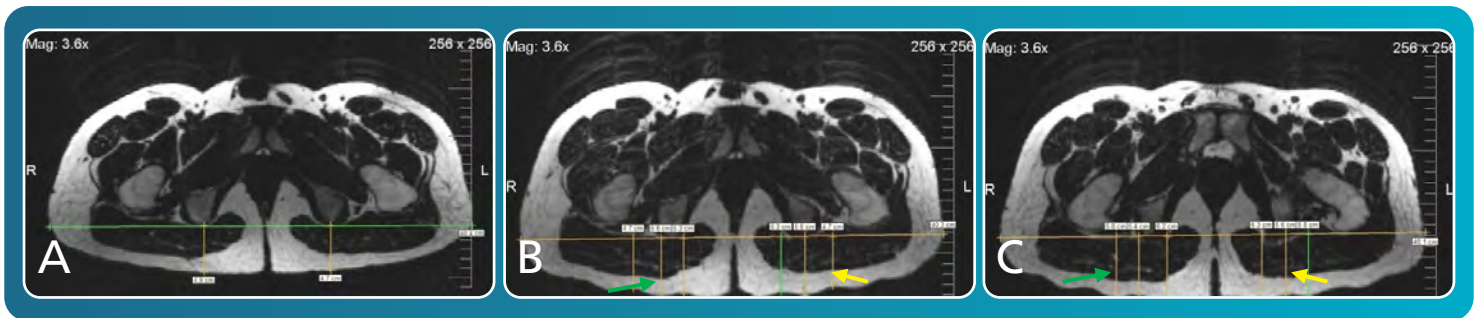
Cross-sectional MRI of pelvic area while lying on the OR pad alone. The compression on various tissues are continuous while lying supine on the OR pad.
